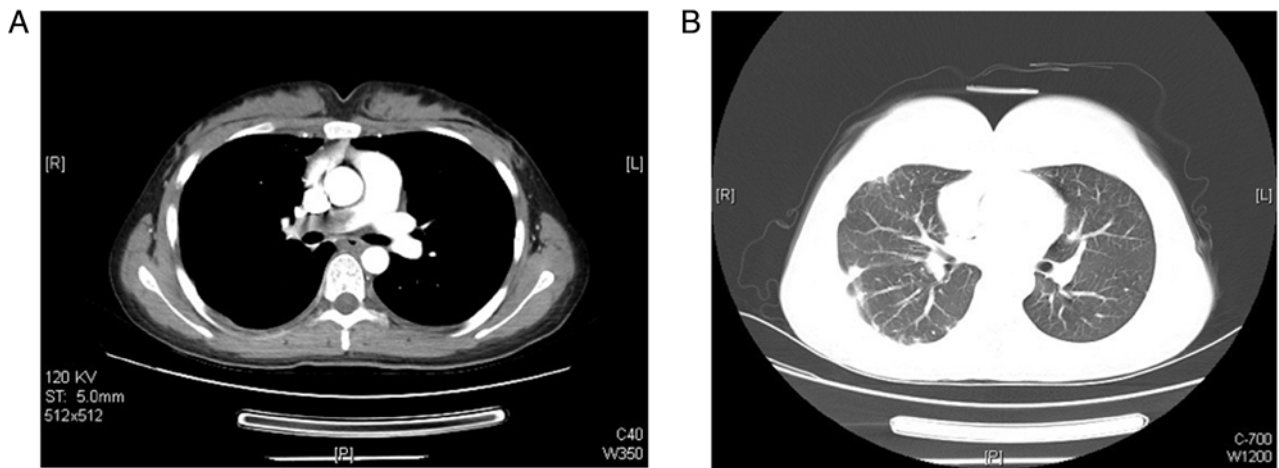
Contrast-enhanced chest CT images of a 21-year-old woman with chorio-carcinoma accompanied by a pulmonary embolism. (A) Contrast-enhanced chest CT (mediastinal window setting) scan image showing occlusion of the right pulmonary artery. (B) Chest CT (lung window setting) scan image showing multiple patchy, cordlike, nodular fuzzy shadows in the right lung. CT, computed topography.
